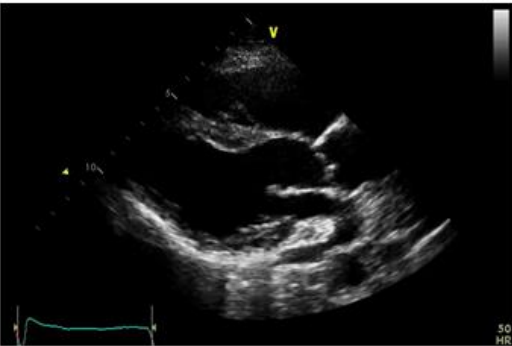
Echocardiography revealing a marked thinning of basal inter-ventricular septum in a patient diagnosed with cardiac sarcoidosis.
